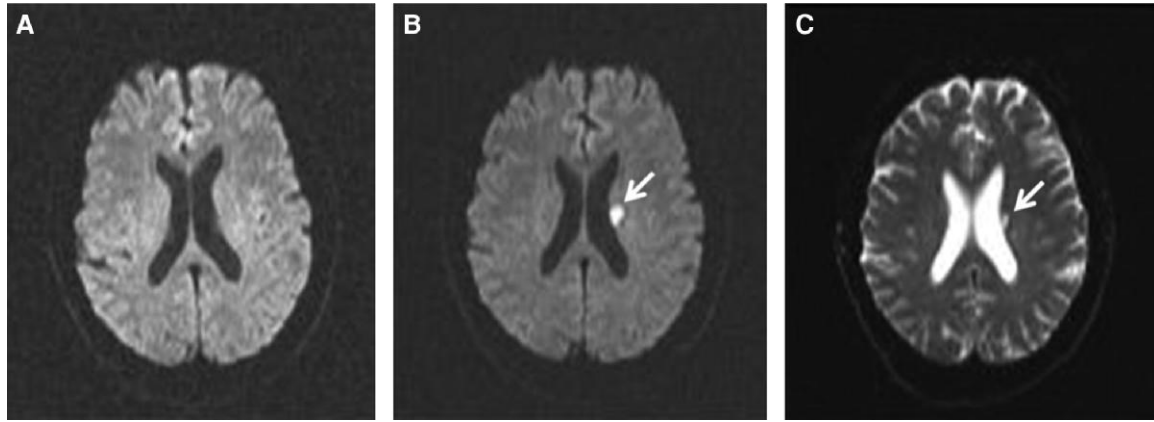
(A) Diffusion-weighted brain magnetic resonance imaging (DW-MRI) prior to pulmonary vein isolation (PVI); (B) DW-MRI post-PVI; and (C) echo-planar T2-weighted MRI at 3 months. Note the presence of a new embolic lesion following PVI which persists at 3 months in this case. Reproduced with permission from Martinek et al.²⁴
